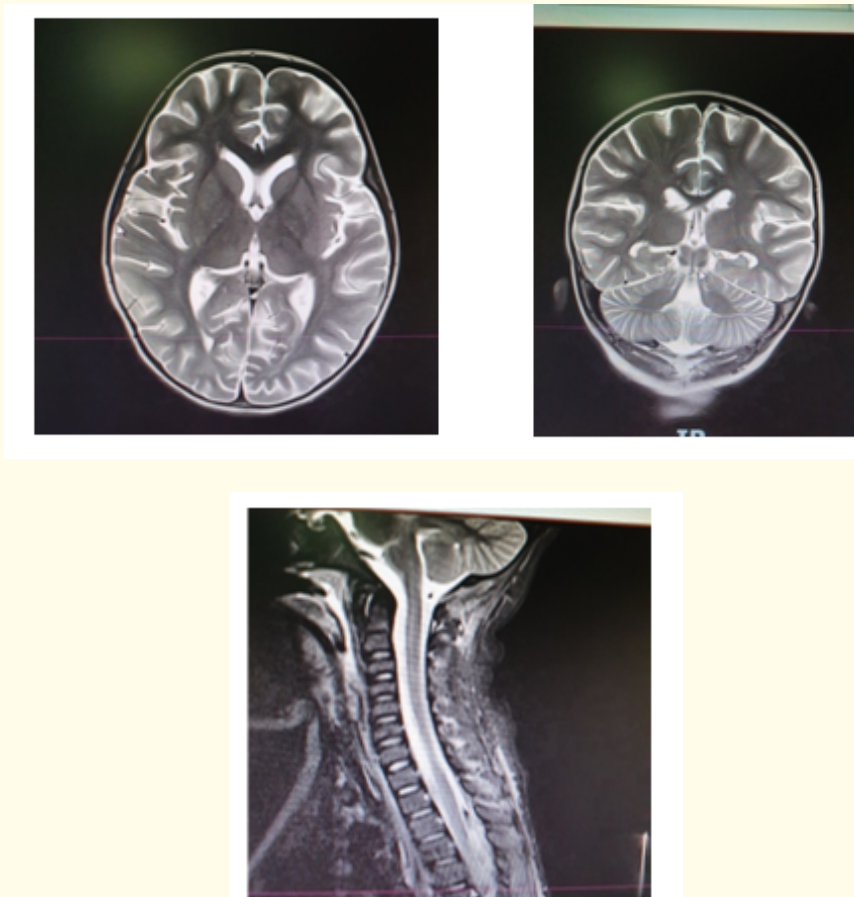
MRI brain T2 axial and coronal cut and spine normal.
